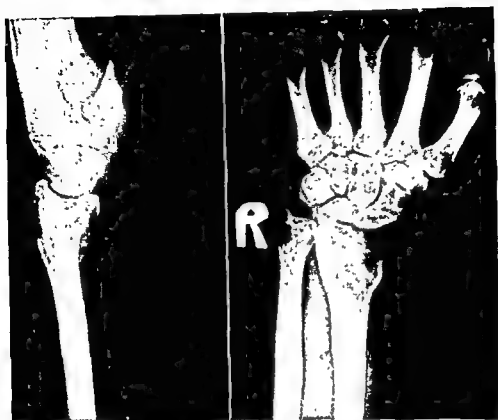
Roentgenogram of a benign giant cell tumor of the lower end of the radius. Note the asymmetrical position of the expanded bone shell in the region of the epiphysis. Trabeculae within the cystic area are seen. The bone shell is perforated on the medial side. This lesion underwent malignant change 10 years later after repeated curettage and postoperative irradiation.
